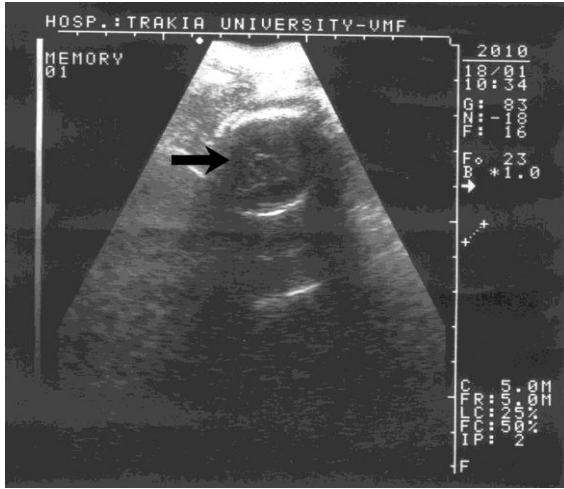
Sonographic visualization of foetal debris.
